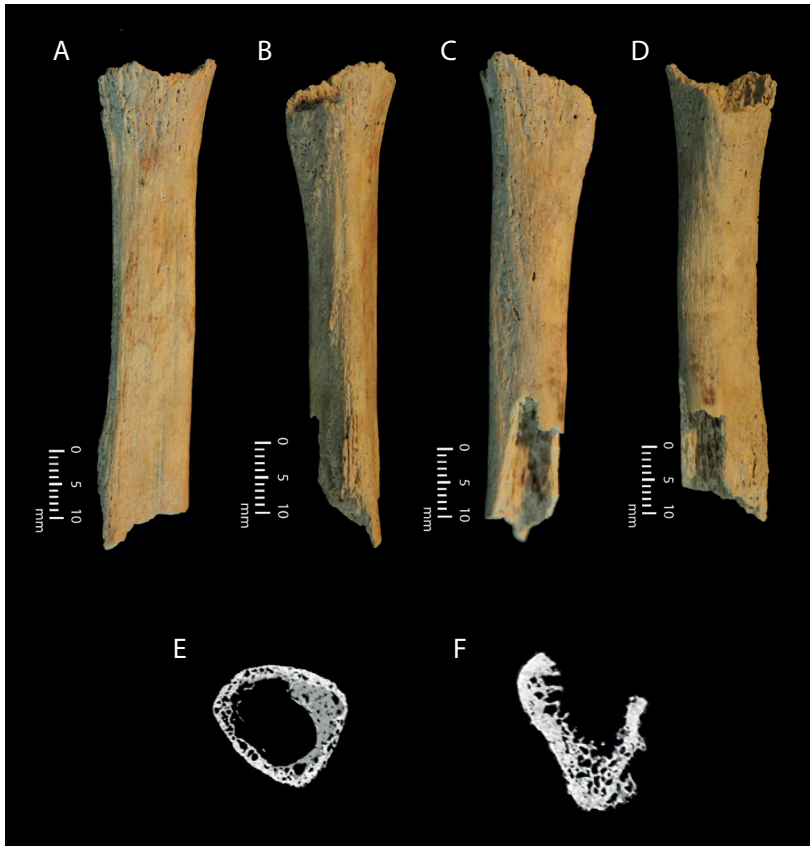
Photographic and radiological images pertaining to fragmented adult right fibula (FB0038) from Context (960) of the Circle sample, depicting periosteal lesions traversing the refitted fragments of the proximal metaphysis and diaphysis, including: a) anterior view; b) medial view; c) lateral view; d) posterior view; e) transverse cross-section from CT data at proximal metaphysis showing sediment adhesion and pockmarked cortex; f) transverse cross-section toward the distal aspect of the extant element showing periosteal deposition on the medial aspect, perpendicular to the cortex. Scale bar: 1 cm (photographs only). Photos Jess E. Thompson; (radiological images captured by L. Buck, Cambridge Biotomography Centre; processed by J. Magnussen & M. Pardey, Macquarie Medical Imaging).*
